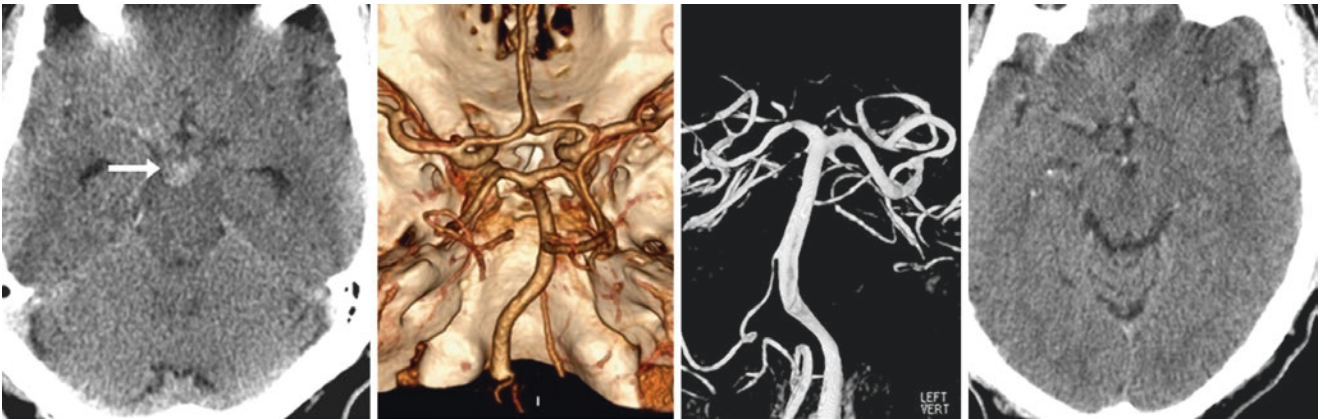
Comparison case of perimesencephalic nonaneurysmal SAH: A 57-year-old with a severe headache had SAH (*arrows*) solely within the interpeduncular fossa on nonenhanced CT (*left*). CTA (*left*
